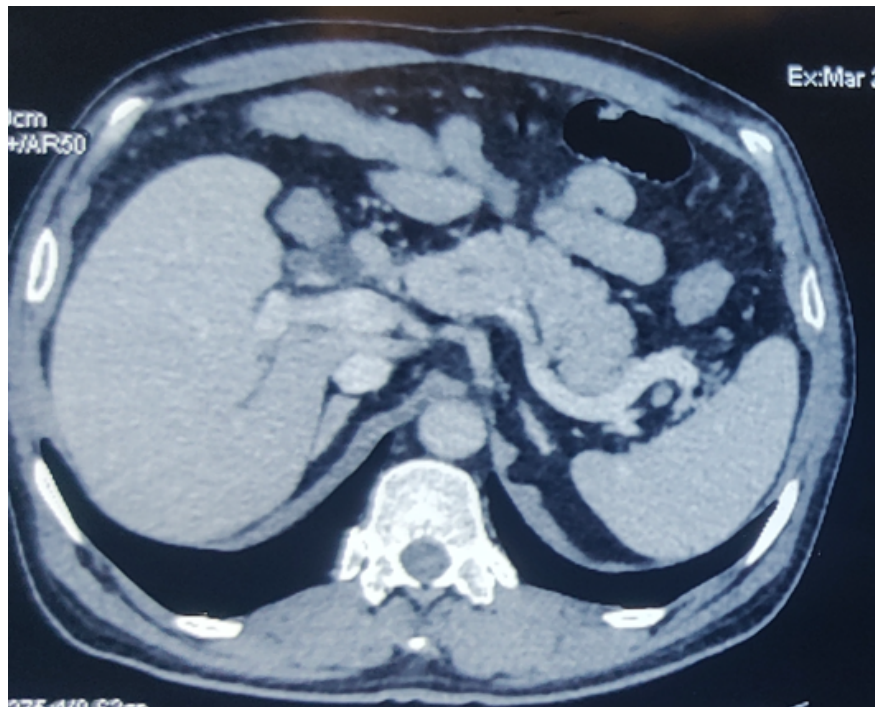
Contrast enhanced CT showing absent segments III and IVB of left lobe of liver
